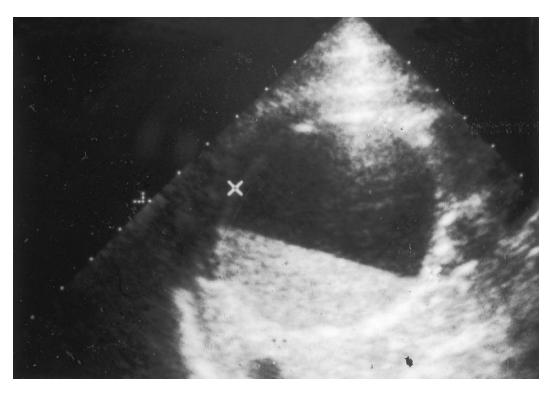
Ultrasound image of a cyst demonstrating fluid levels. This is another example of a complicated ovarian cyst.
